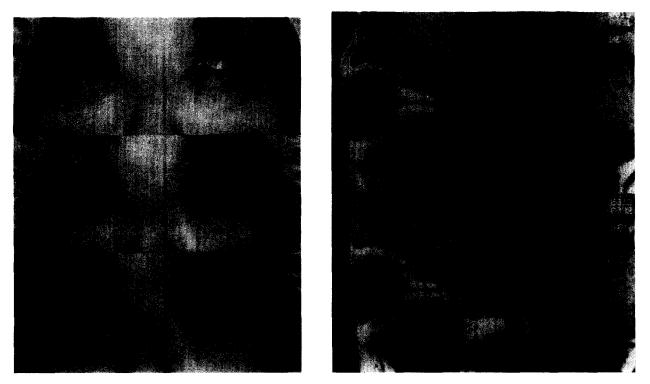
(A: left) Left hypertropia and overaction of left superior rectus muscle in up, primary, and down gaze (Case 2). (B: right) Saggital MRI focal enlargement of left superior rectus muscle (top: right eye; bottom: left eye) (Case 2).
